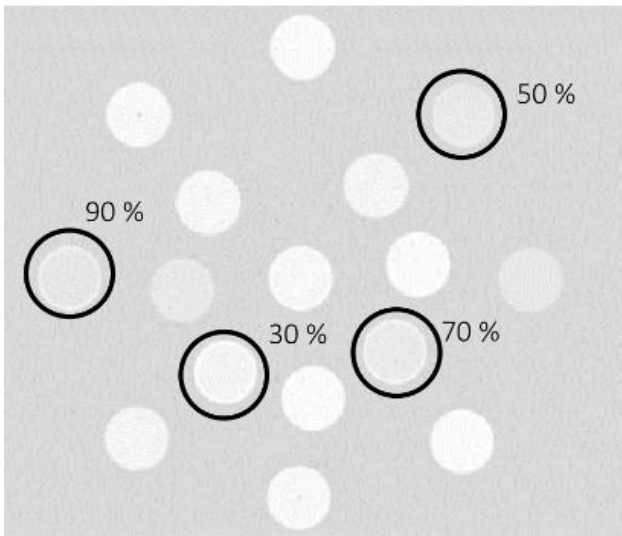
Transversal CT-scan with cubic infill samples highlighted.
